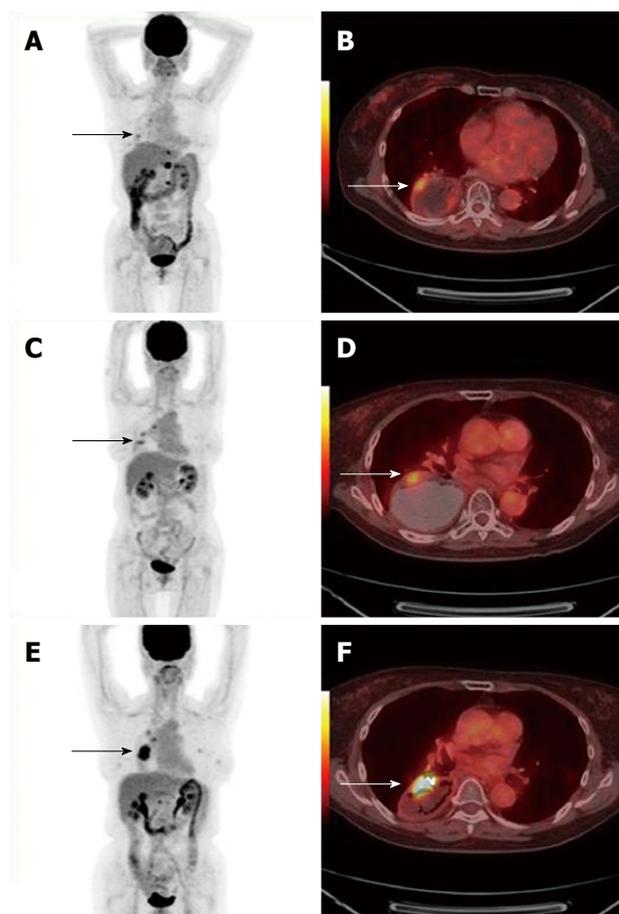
A 56-year-old woman with metachronous gastric cancer after esophageal cancer resection 5 years ago. Positron emission tomography/computed tomography (PET/CT) displayed multi-retroperitoneal lymph node recurrence (arrow in A), which was later verified as esophageal cancer metastasis (squamous cell carcinoma). PET revealed a small lesion at gastric tube, but endoscopy was negative (arrows in A, B, C, D). Third PET/CT showed an enlarged gastric lesion, and endoscopic biopsy verified gastric tube cancer (adenocarcinoma) (arrows in E, F).
